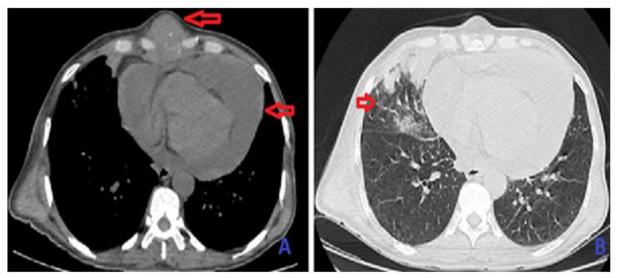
Sagittal CT scan of the thorax
